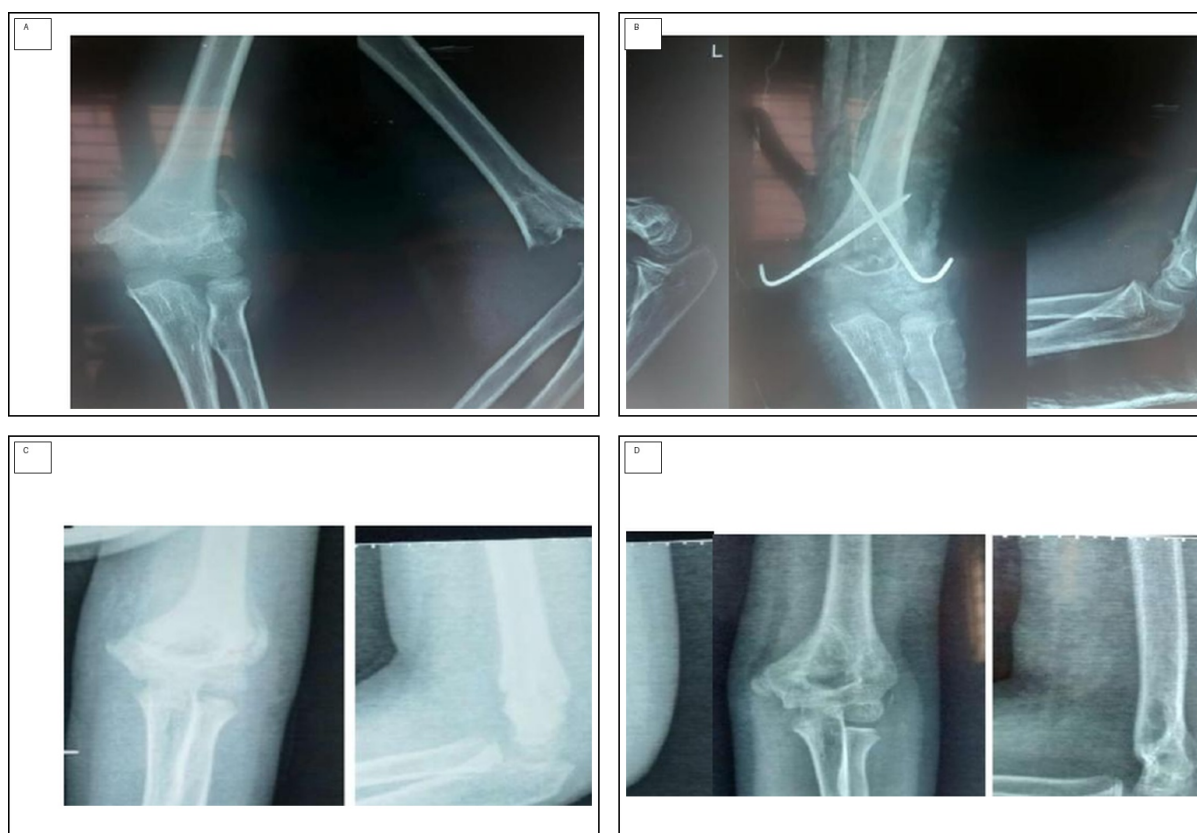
Representative radiographic course in a six-year-old boy with a left Gartland type II supracondylar humerus fracture. (A) Preoperative radiographs. (B) Immediate postoperative crossed-pin fixation. (C) Four-week follow-up. (D) Six-month follow-up showing maintained alignment and healing.
